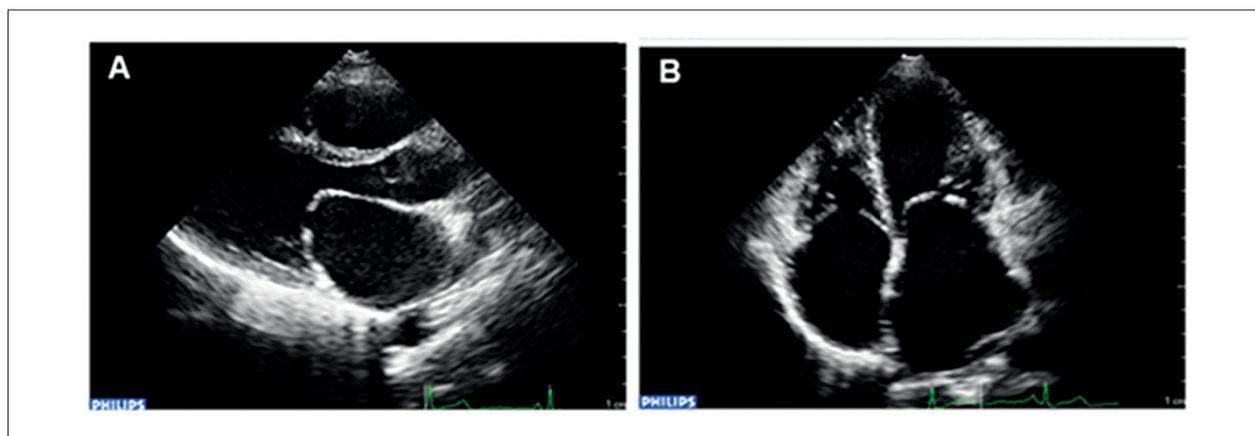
Rheumatic mitral stenosis (RMS) with favorable anatomy. 2D transthoracic echocardiogram (TTE): parasternal long-axis view (A) and apical four-chamber view (B), showing mitral valve with thin, mobile leaflets without calcification, consistent with anatomy favorable to PMBV.
